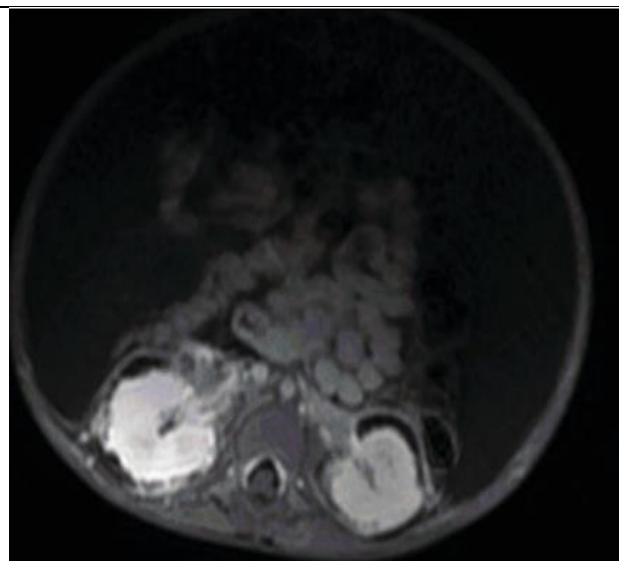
Axial segment of bilateral perirenal fluid accumulation, compared and mentalized, manifesting as T1 hypointensity on MRI.
